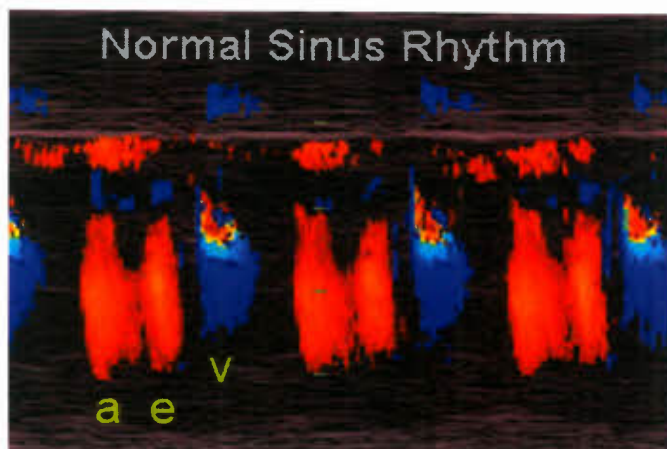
Color-encoded M-mode echocardiogram. The M-mode tracing imparts temporal resolution to the color flow recording. In this orientation, diastolic filling of the fetal ventricle is toward the transducer, resulting in the biphasic e and a waves, whereas the ejection into the aorta is away from the transducer and is inscribed as the aliased blue/cyan image.
